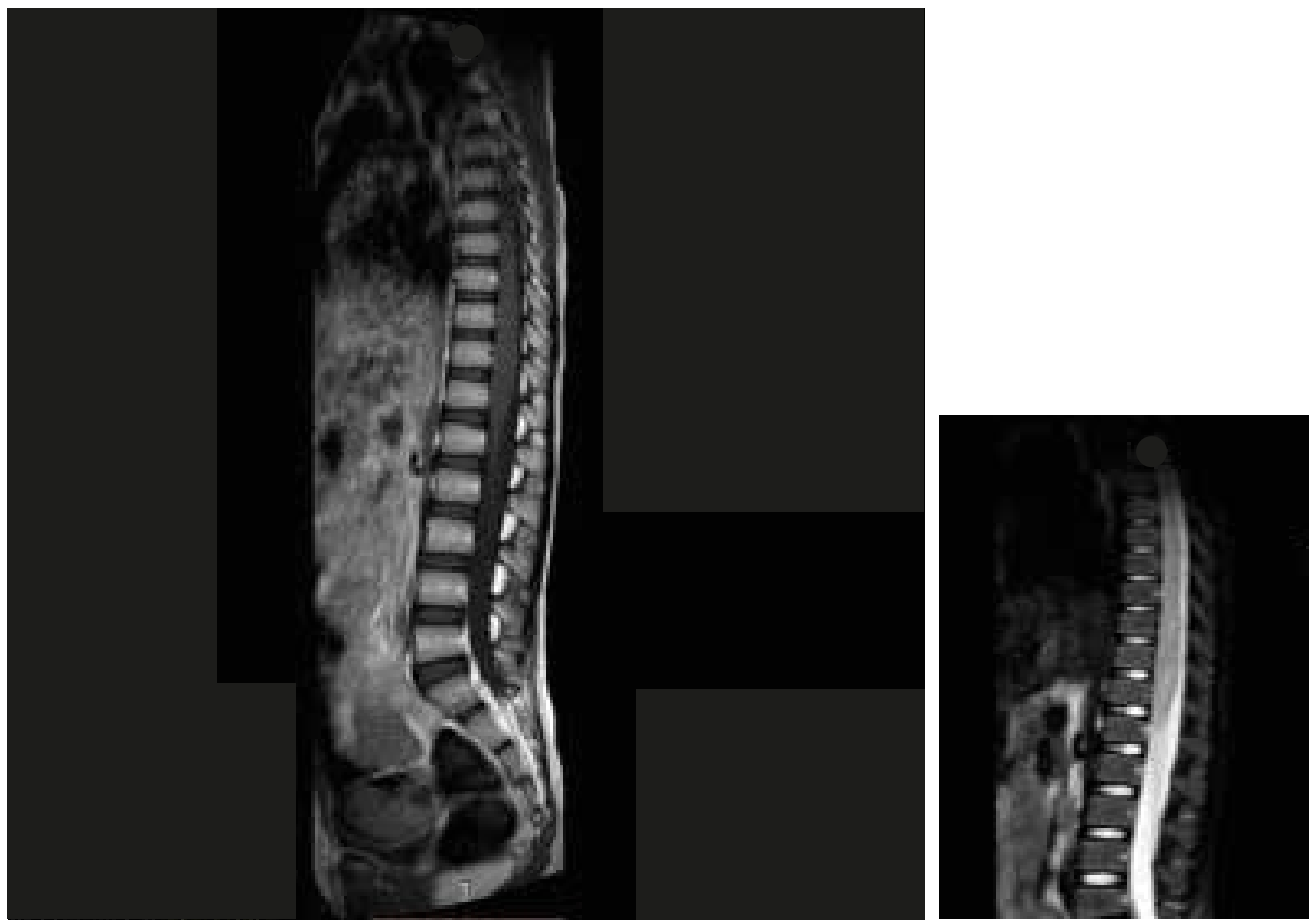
MRI of the cervicodorsal spine T2 and contrast-enhanced images showing involvement of central cord
